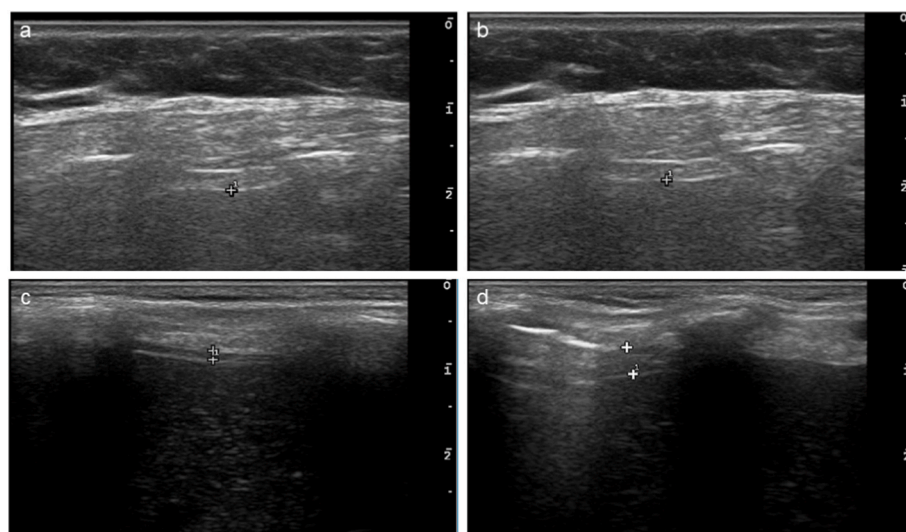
Ultrasound of the diaphragm in LAMA2-MD and SELENON-RM patient. (a) Ultrasound of the diaphragm of a SELENON-RM at end-expiration showing no identifiable diaphragm at end expiration. (b) Ultrasound of the diaphragm of the same SELENON-RM patient showing no identifiable diaphragm at maximal inspiration. The marker in images a and b indicates the position where the diaphragm should be located. Note, that just above the marker a muscle layer is visible. However, through extensive scanning we identified this muscle layer as the intercostal muscles and not the diaphragm. (c) Ultrasound of the diaphragm of a LAMA2-MD patient showing a normal diaphragm thickness (DTend-exp = 1.0 mm). (d) Ultrasound of the diaphragm of the same LAMA2-MD patient with evident diaphragm thickening (DTmax-insp = 3.2 mm).
